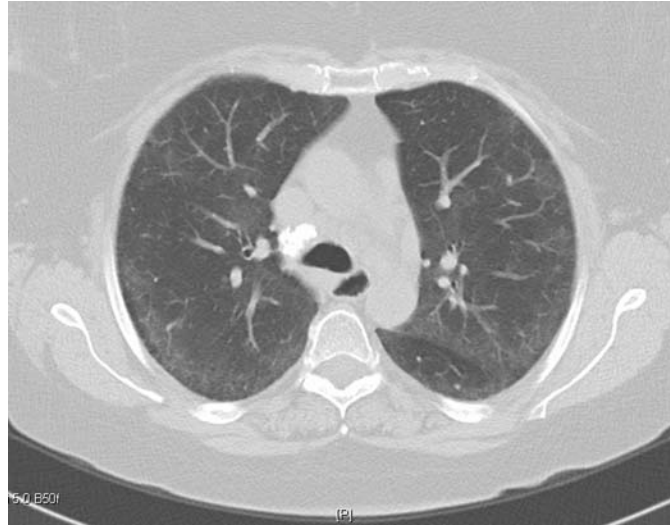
FIGURE e24-27 CT scan of diffuse, bilateral “ground-glass” infiltrates. This finding is consistent with fluid density in the alveolar space.
